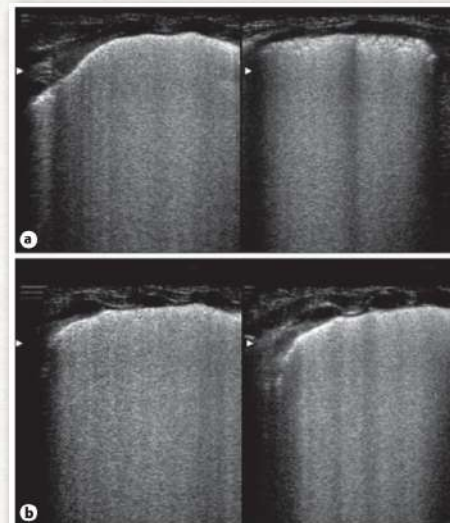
a Lung appearance before surfactant administration: evidence of echographic 'white lung'. b Lung appearance 14 h after surfactant administration the ultrasound lung picture is not substantially changed.
